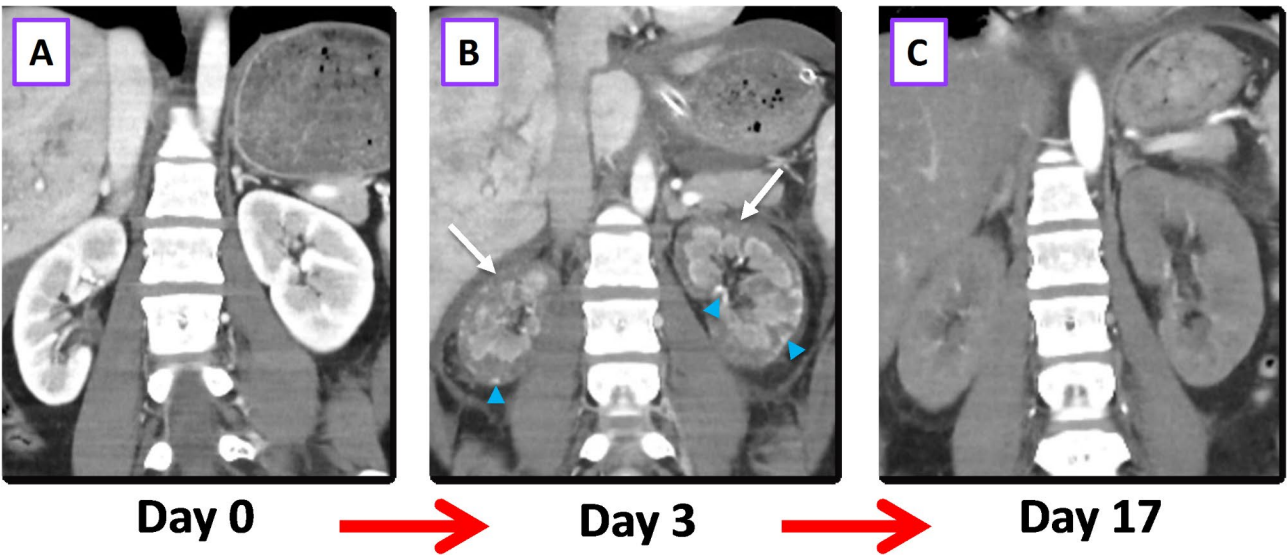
Contrast-enhanced computed tomography (coronal images). (A) At admission: normal kidney enhancement and preserved cortico-medullary differentiation. (B) At day 3: association of diffuse hypoattenuating cortical enhancement (white arrows) with intact medullary enhancement in both kidneys corresponding to the “reverse rim sign” and consistent with bilateral acute renal cortical necrosis. Of note, perfusion of subcapsular and juxtamedullary regions seemed preserved within the cortex (blue arrowheads). (C) At day 17: bilateral and complete corticomedullary dedifferentiation probably indicative of progressive renal reperfusion of the cortex
